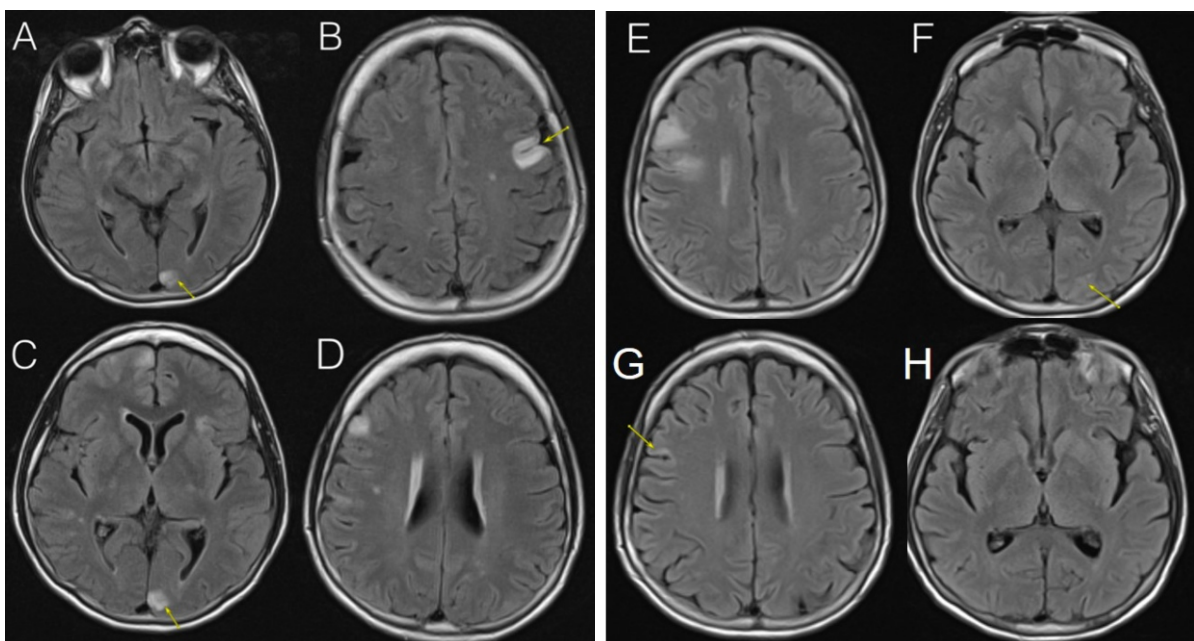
Demonstrates evolution of MRI changes throughout the course of the disease. MRI brain FLAIR sequence on initial presentation with left occipital lesion (A) and left frontal lesion (B); short interval follow-up a few weeks later, after five-day steroid treatment, with persistent occipital lesion (C) and interval development of a new right frontal lesion (D). FLAIR sequence three months after initial presentation, prior to immunotherapy, demonstrating evolution of R frontal lesion (E) and resolution of L occipital lesion (F); FLAIR sequence seven months after initial presentation, after IVIG and chemotherapy administered, with only minimal residual right frontal gliosis (G) and no recurrence of occipital lesion (H).
